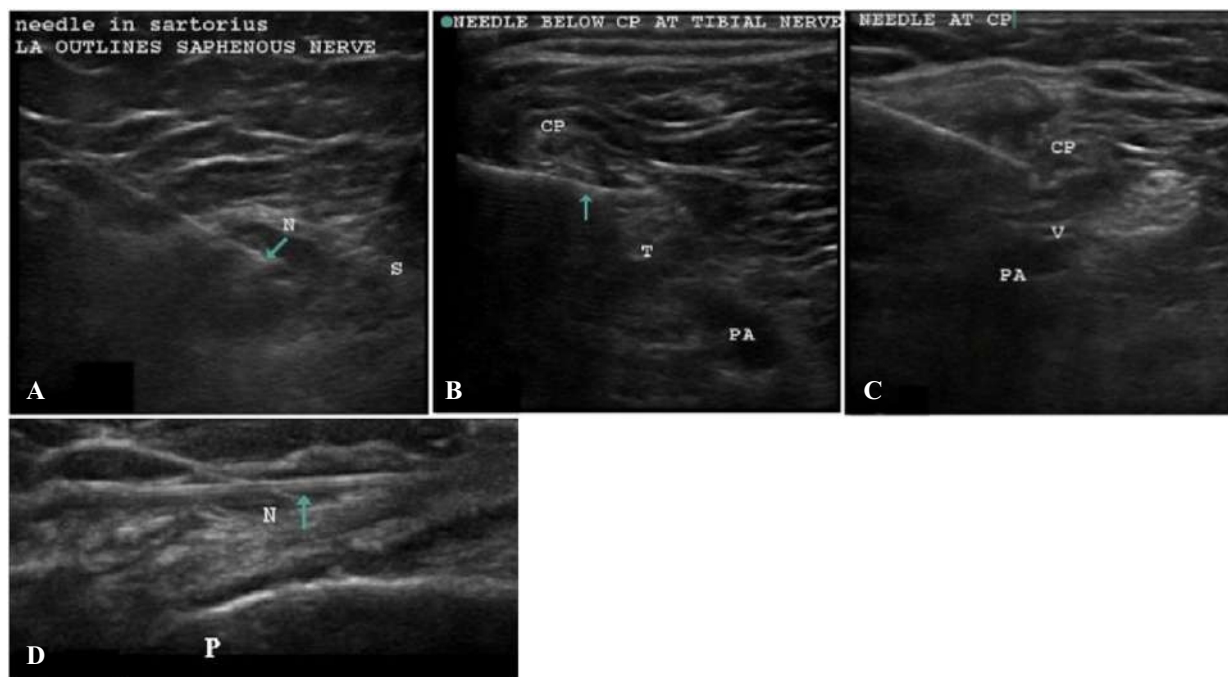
(A) Ultrasonography-guided saphenous-nerve pulsed radiofrequency (PRF) at lower end of thigh. (B) Ultrasonography-guided tibial nerve PRF. Arrow showing needle at tibial nerve. CP, common peroneal nerve; T, tibial nerve, PA, popliteal artery. (C) Ultrasonography-guided common peroneal nerve PRF. Needle at common peroneal nerve (CP). V, popliteal vein; PA, popliteal artery. (D) Ultrasonography-guided peripatellar PRF. Needle (N) above patella (P).
